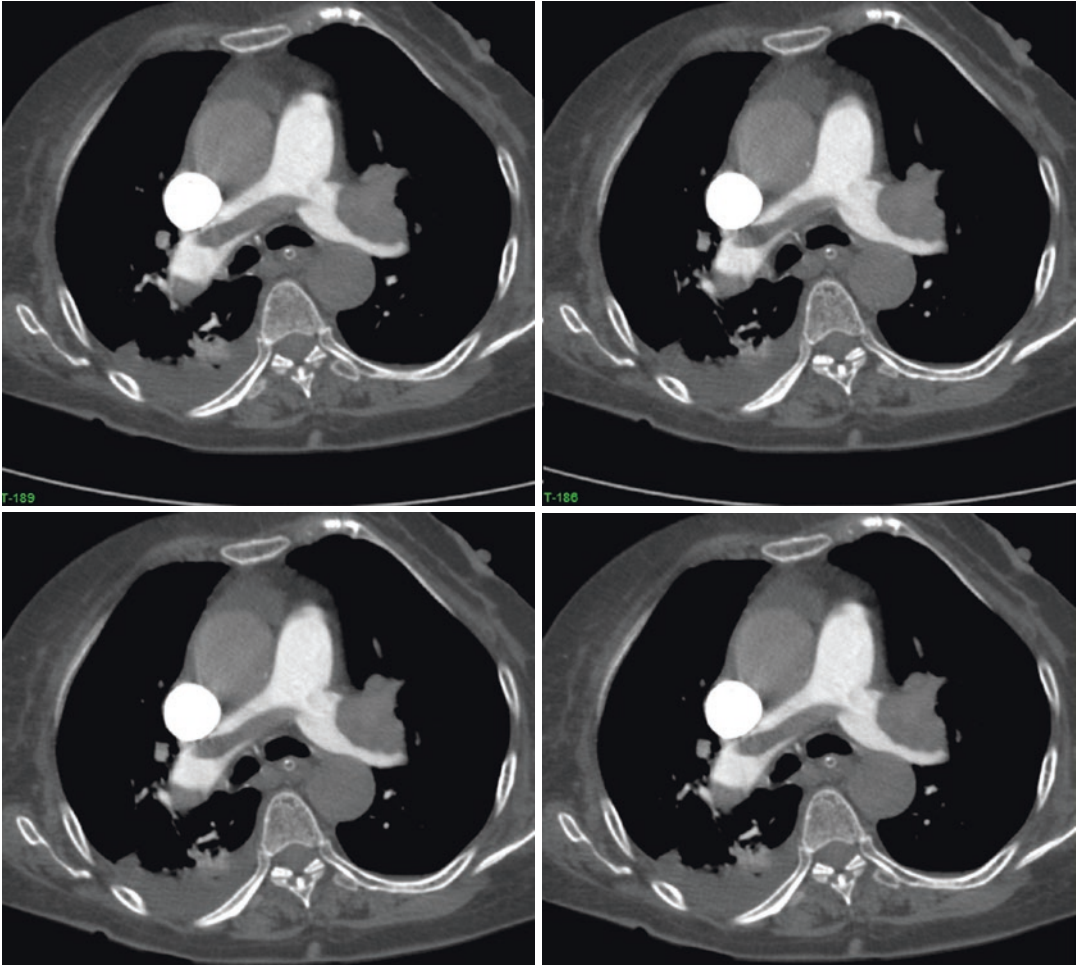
CT pulmonary angiography of pulmonary embolism in an 85-year-old man. 2D axial image show large filling defects in the left and right main pulmonary
